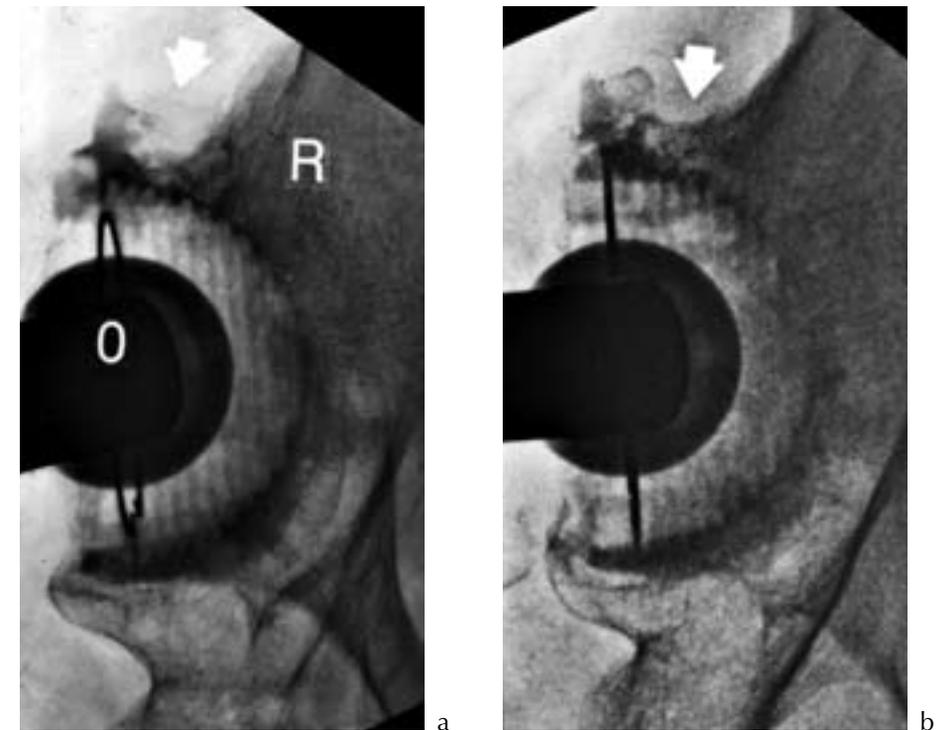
a and b Radiographs of a 68-year old female patient .
